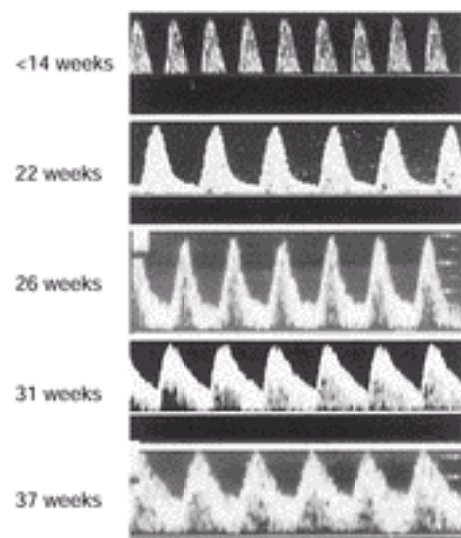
Doppler flow velocity waveform profiles in the umbilical artery across normal gestation. Note the progressive increase in end-diastolic flow.
